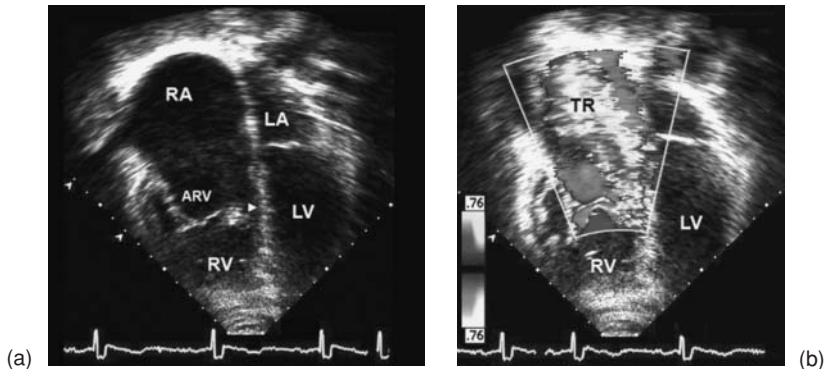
Apical four-chamber, two-dimensional transthoracic echocardiographic image (a) demonstrates apical displacement of the septal tricuspid valve leaflet (arrowhead) compared with the anterior mitral valve leaflet, and tethering of the anterior tricuspid leaflet. There was associated (b) severe tricuspid valve regurgitation noted by color Doppler imaging. RA, right atrium; RV, right ventricle; ARV, atrialized right ventricle; LA, left atrium; LV left ventricle; TR, tricuspid regurgitation.
